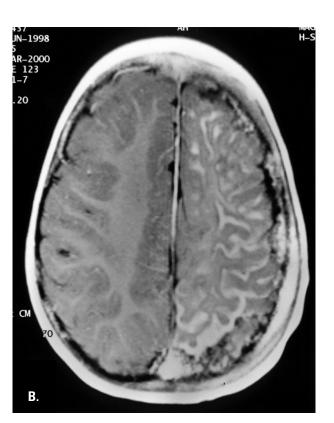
A*, Coronal T_2 -weighted magnetic resonance imaging (MRI) scan showing left hemisphere atrophy and prominent subarachnoid space. *B*, Axial gadolinium-enhanced MRI reveals atrophy and prominently enhancing leptomeningeal angiomatosis. *C*, Coronal gadolinium-enhanced MRI also shows prominent left choroid plexus.
